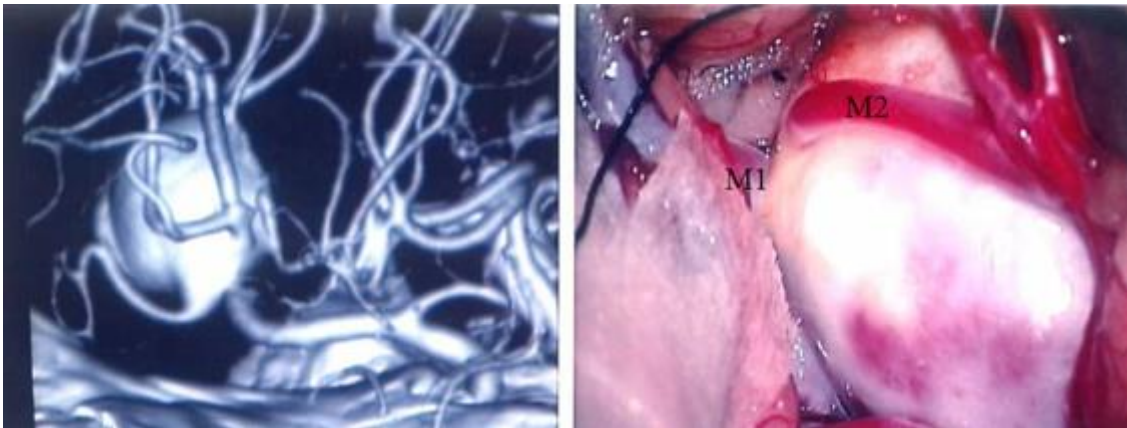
3D CTA and intraoperative image of a type III aneurysm
